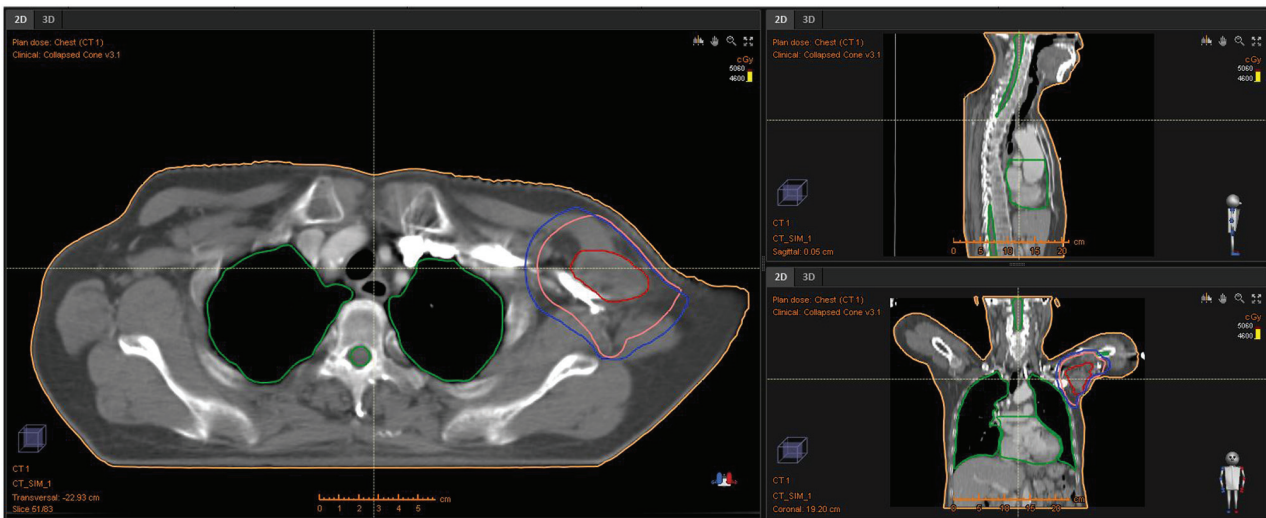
The 64-row computed tomography images indicated the target area range of postoperative therapeutics, including nine-field intensity-modulated radiotherapy targeted to the left axilla.
